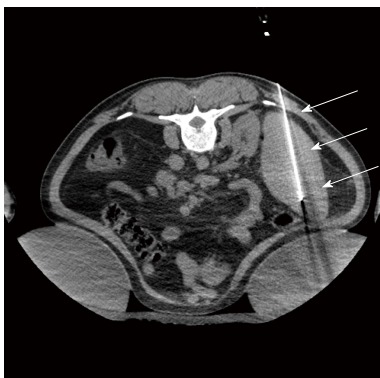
Axial non-enhanced computed tomography scan guiding the splenic radiofrequency ablation, with the patient in the prone position. Note the "single" probe (arrow) in the middle/ lower third of the spleen. where the ablation zones were concentrated.
